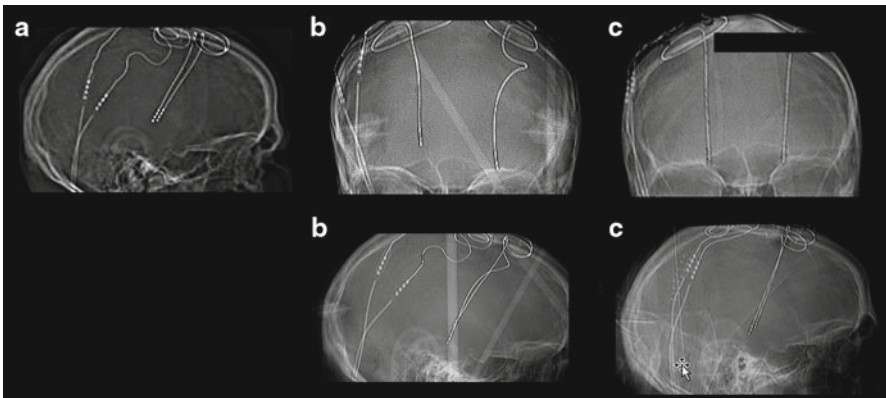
Ventral lead migration shown by serial X-rays. (a) A skull X-ray at 1 month postimplantation. (b) A skull X-ray at 14 months following first operation. The left and right leads had moved approximately 16 and 5 mm downwards from the initial position, respectively. (c) A skull X-ray at 1 month following lead replacement (adapted from [2], used with permission of Elsevier)
